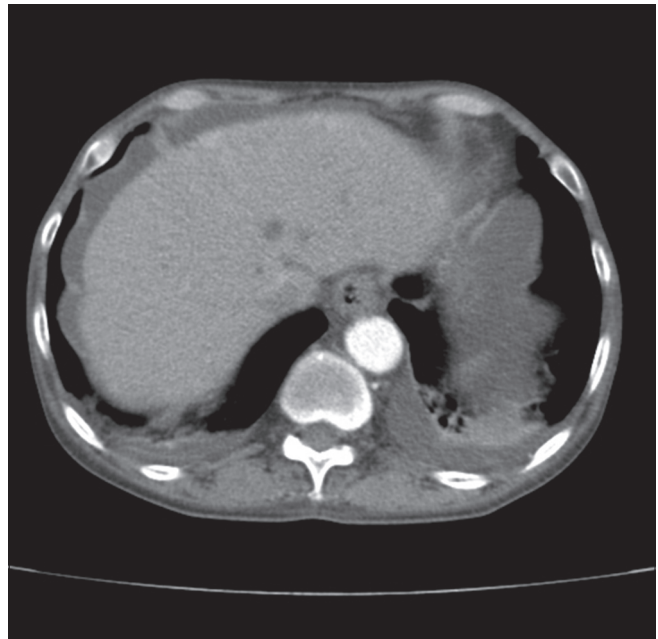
Computed tomogram showing multiple non-enhancing hypodense lesions involving bilateral hepatic lobes
